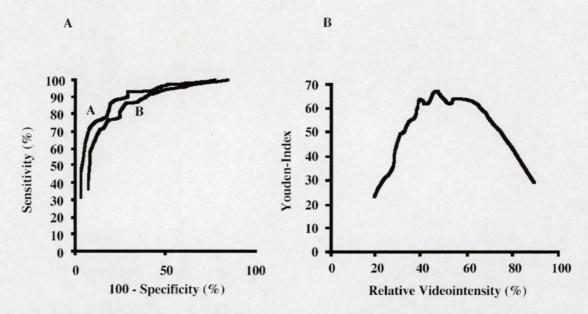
Receiver operator characteristic curves for identification of functional recovery or presence of contractile reserve (curve A) or functional recovery alone (curve B) by contrast echocardiography. (B) The Youden index (sensitivity + specificity-100) of different relative videointensities for the prediction of functional recovery or presence of contractile reserve at two weeks' follow-up.
